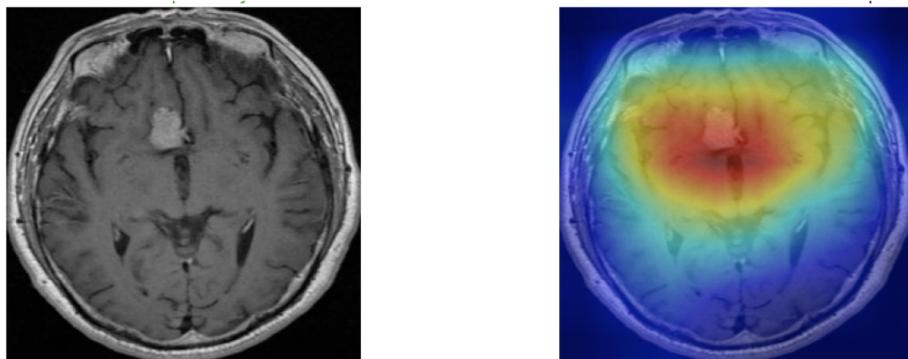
Original MRI image (left) and Grad-CAM visualization (right).
